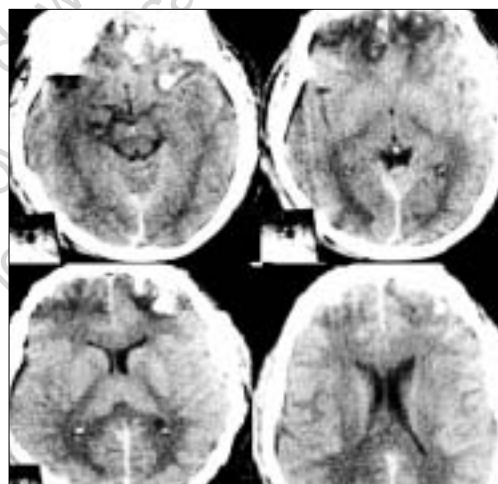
First CT scan of case 3 showing an acute SDH in left fronto-temporo-parietal region and bifrontal contusions more on left side
